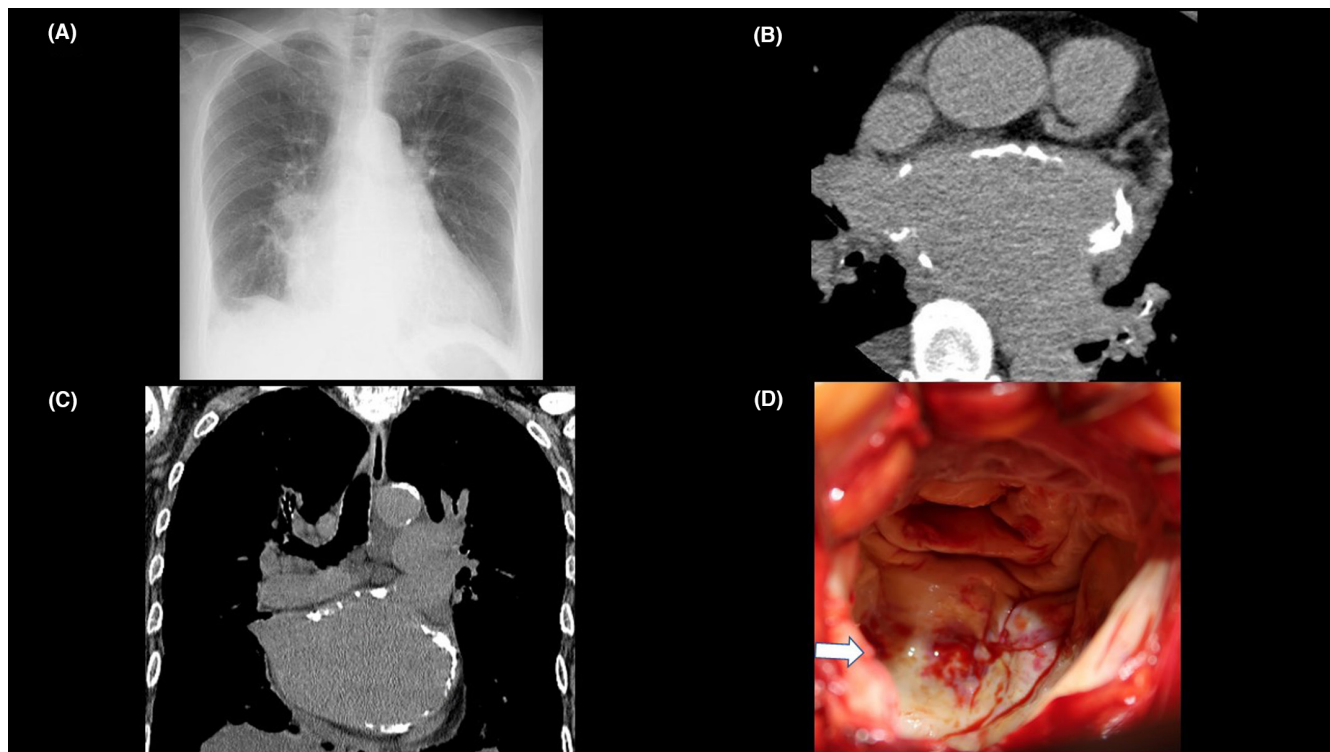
(A) Chest X-ray at the admission. (B) The plain chest computed tomography (CT) showed left atrial massive calcification (axial view). (C) The plain chest computed tomography (CT) showed left atrial massive calcification (coronal view). (D) The left atrium was wholly calcified, as in CT.
